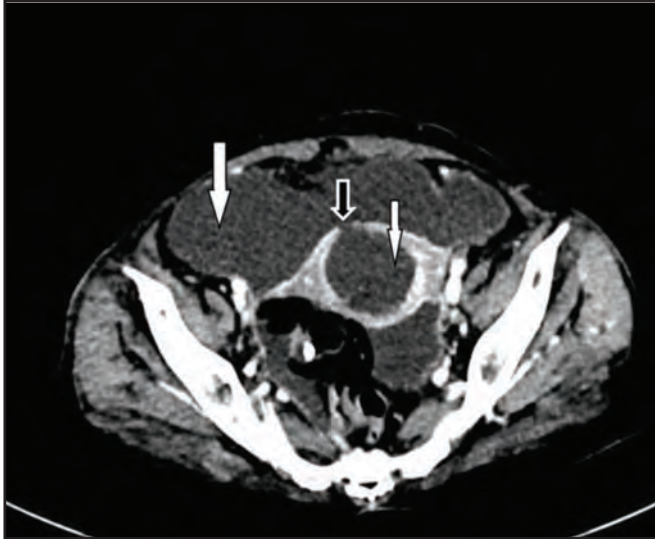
Axial view (pelvic level) contrast enhanced CT scan demonstrating distended fluid filled endometrial cavity (white solid arrows) consistent with pyometra. Loculated collection (hollow white arrow) consistent with pyoperitoneum is seen in lower abdomen. Also seen is a small defect along anterior wall of uterine corpus marked by black arrow
